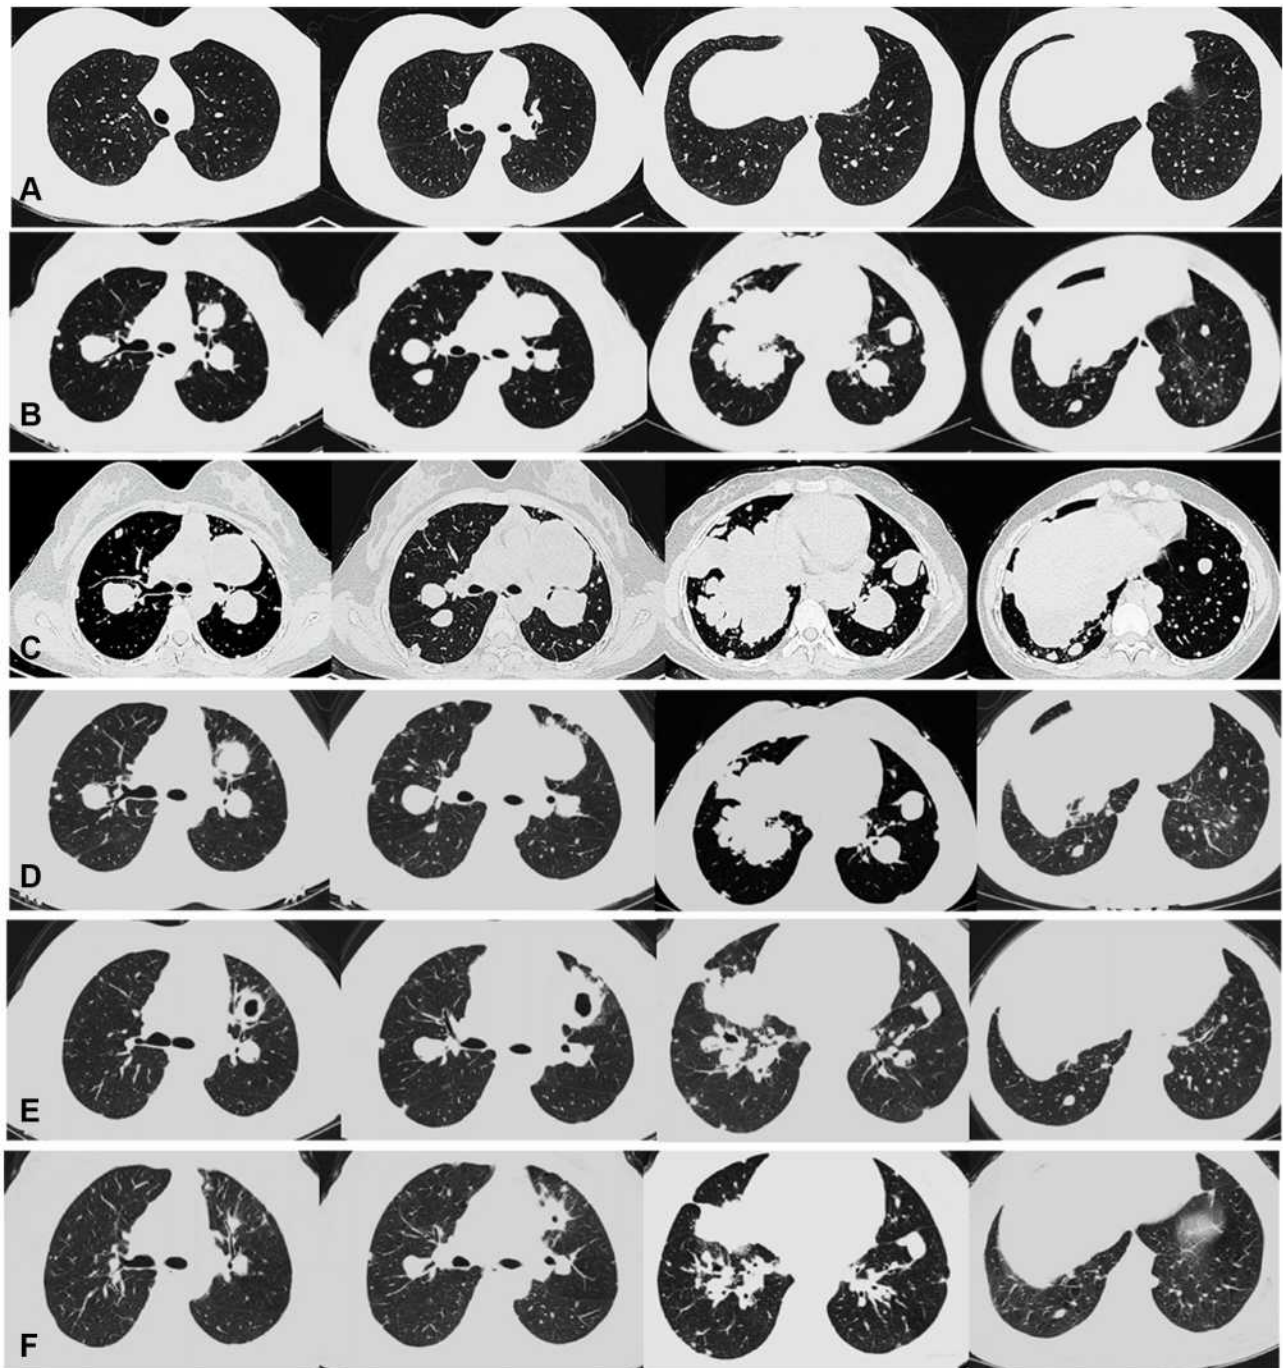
CT of the chest. (A) Local recurrence but without pulmonary metastasis. (B) Multiple pulmonary metastases were found and denosumab initiated. (C) 4 months after denosumab therapy. (D) 3 months after denosumab and apatinib therapy. (E) 15 months after denosumab and apatinib therapy. (F) 33 months after denosumab and apatinib therapy.
